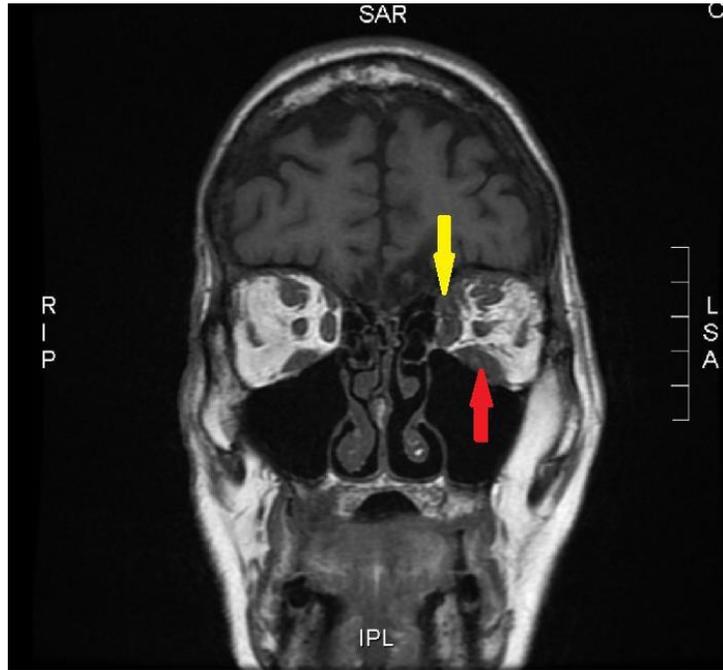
MRI displaying significant asymmetry of EOM involvement. Inferior (red arrow) and medialrectus (yellow arrow) of the left eye were thickened compared to the right eye.
